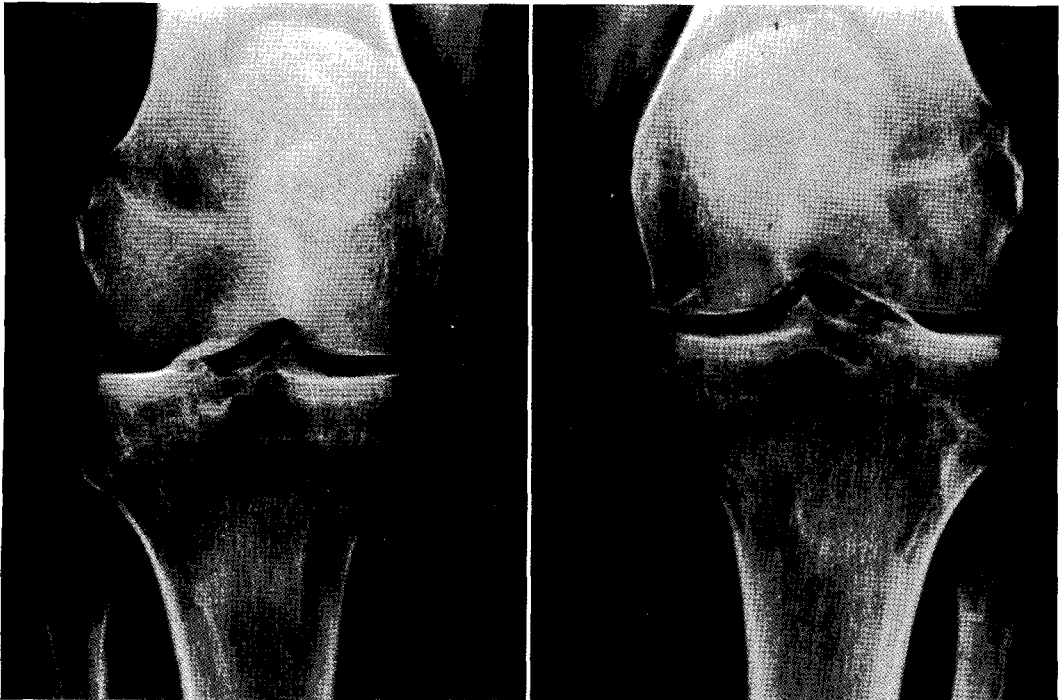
Case 1. X-ray: Arthrosis of both knees, more on the left side.
